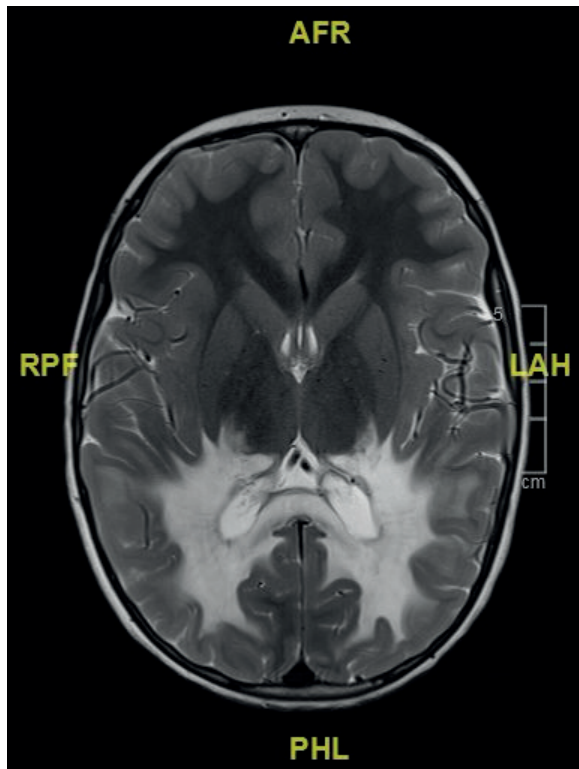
MRI revealed cerebral demyelination with white matter hypersignal on T2 sequences at the medulla oblongata, pons, splenium of the corpus callosum and parietooccipital lobes
